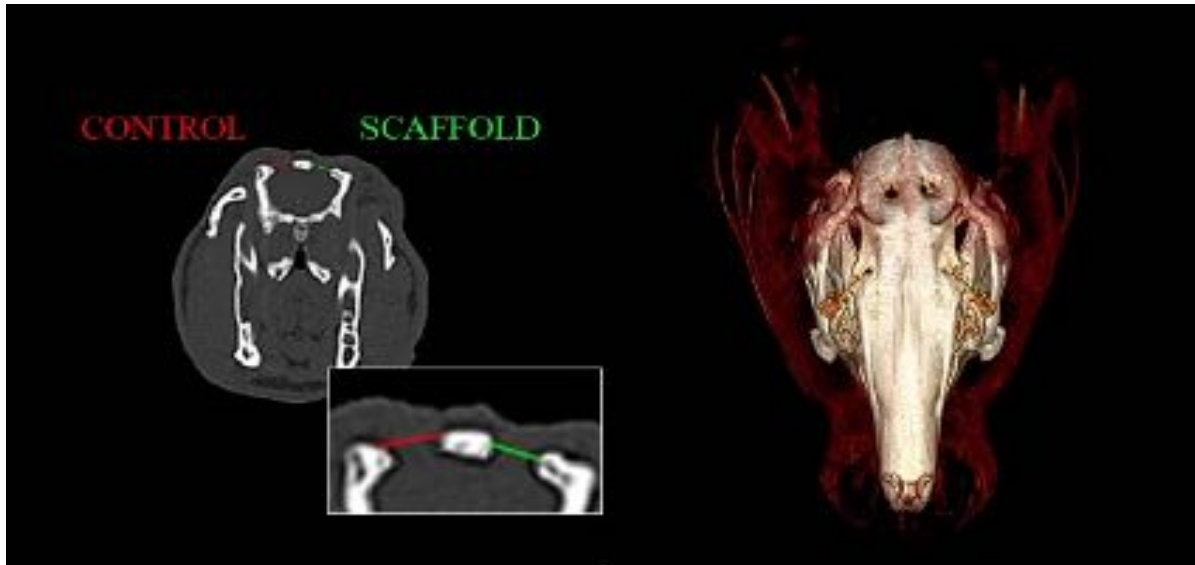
CT scan and 3D reconstruction at 4 weeks. A comparison of the diameters of treated versus untreated bone defects is demonstrated in the coronal view.
